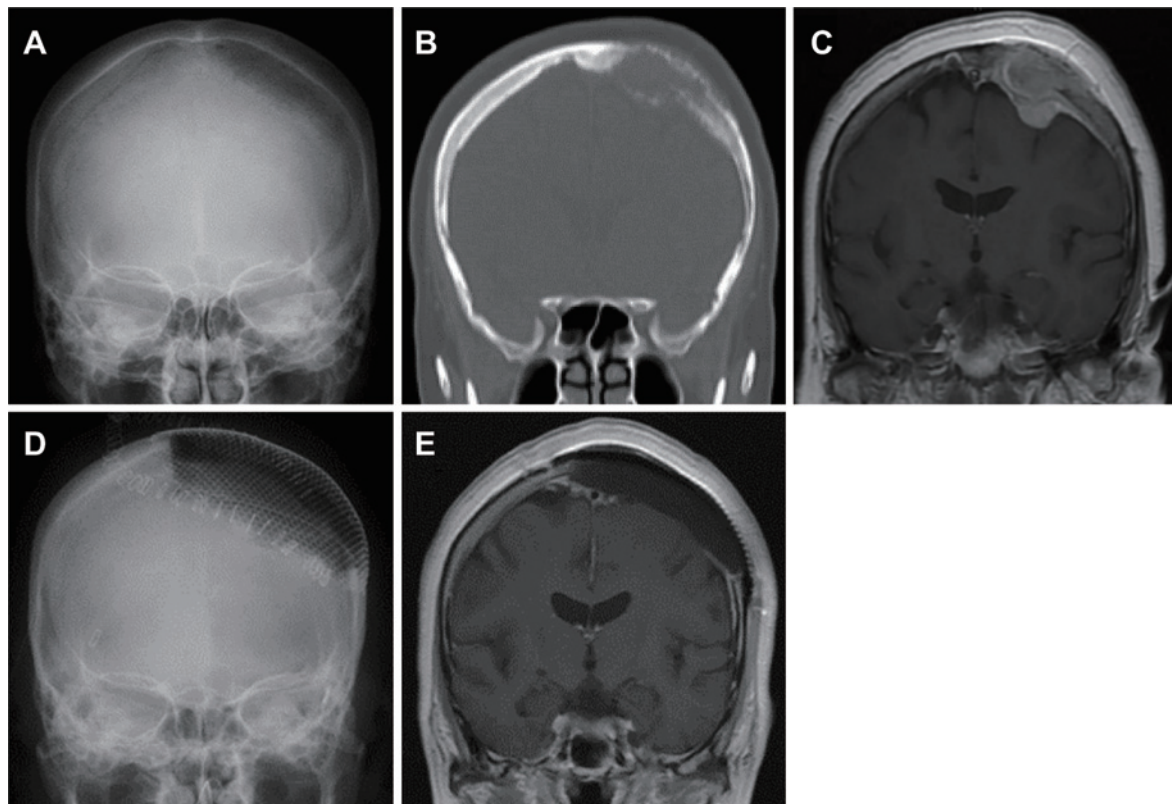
Preoperative and postoperative radiographic findings. A, B: Preoperative skull radiograph and CT scan with a bone window showing an osteolytic change through the left frontal to the parietal bone. C: Preoperative coronal Gd contrast-enhanced MRI depicting a large, heterogeneously contrasted mass within the left parietal bone, with extensive invasion of the skull, intradural and intracranial epidural spaces, and subcutaneous tissue. D: Postoperative skull radiograph displaying cranioplasty with a custom-made titanium mesh after the lesion resection. E: Gd contrast-enhanced MRI demonstrating total resection of the lesion. CT; computed tomography, MRI; magnetic resonance imaging
